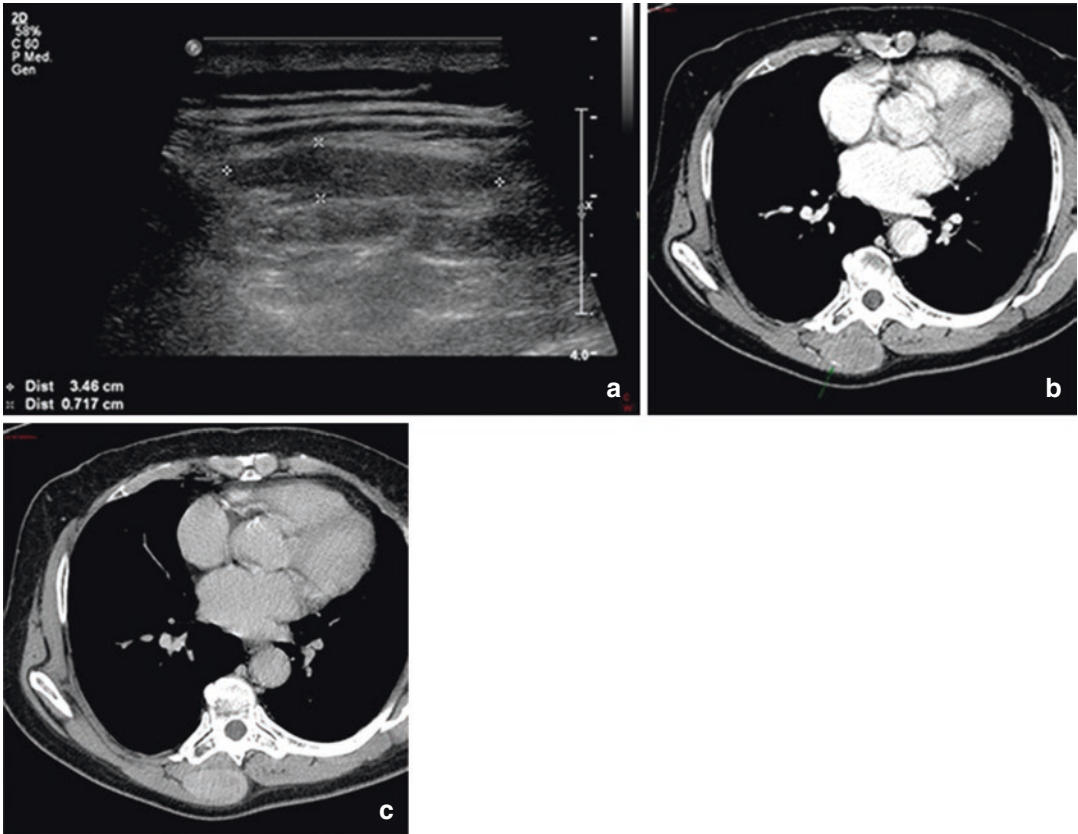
Desmoid thoracic wall. Tumefaction of the back, in the paramedian area, with an ultrasound appearance (a) of an elongated subfascial lesion, hypoechogenic with regular contours, with scarce signals at
